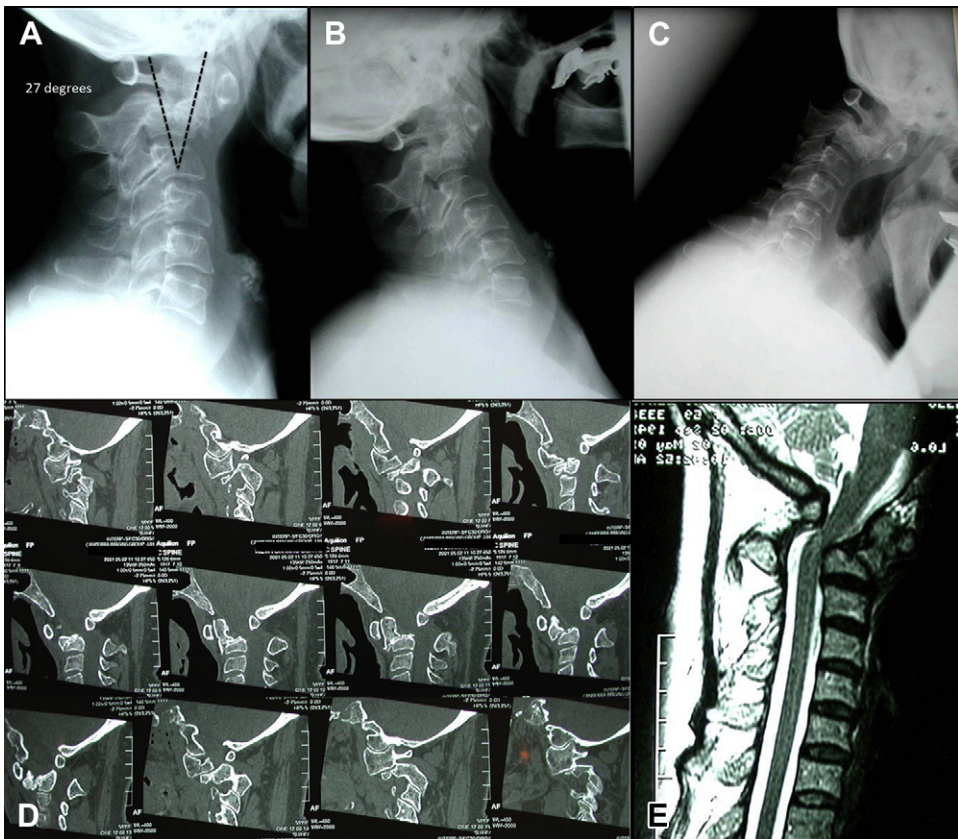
(A–E) A 59-year-old woman with history of rheumatoid arthritis and severe suboccipital neck pain and early signs of myelopathy, 6 months following a motor vehicle accident resulting in type III odontoid fracture, managed conservatively in SOMI (sternal occipital mandibular immobilizer) brace. Plain radiographs, CT scans, and magnetic resonance imaging (MRI) show (A–C) development of fixed 27° kyphotic deformity, (D) bilateral facet joint dislocations, and (E) spinal cord compression.
